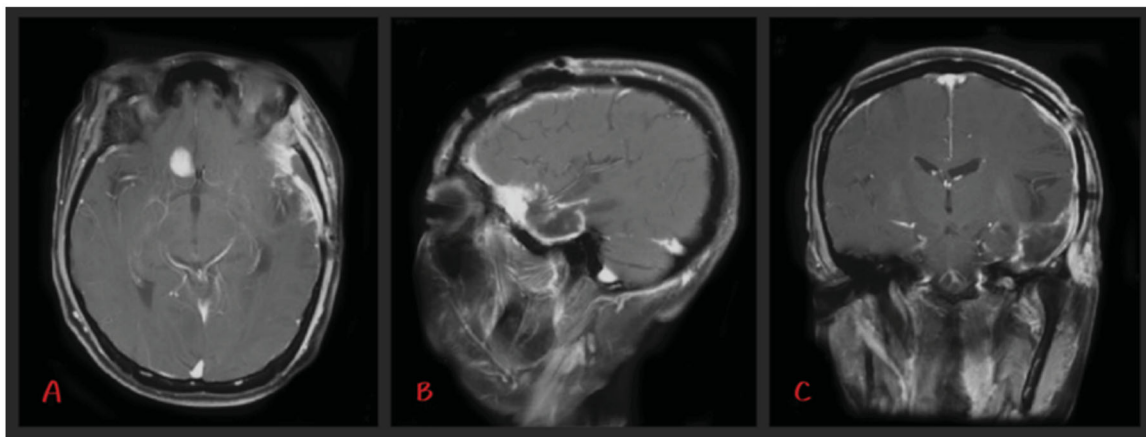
Postoperative brain MRI images. (A) Axial view, contrast-enhanced T1WI. (B) Sagittal view, contrast-enhanced T1WI. (C) Coronal view, contrast-enhanced T1WI.
